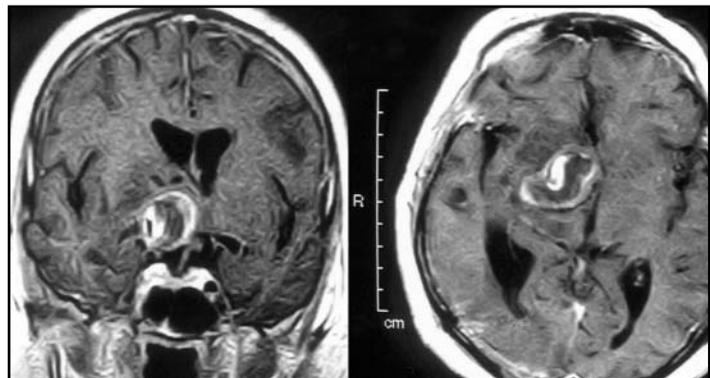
Magnetic resonance imaging (one year after the first surgery) demonstrating total removal of tumor. No change in aneurysm's size.
